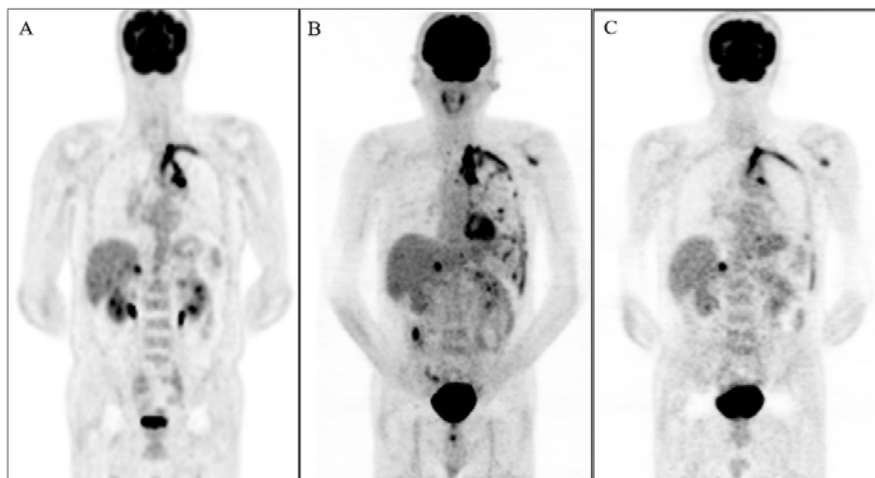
FDG-PET showed progression of uptake of FDG in lesions. (A and B): Before chemotherapy; (C): After 2<sup>nd</sup> line chemotherapy.
